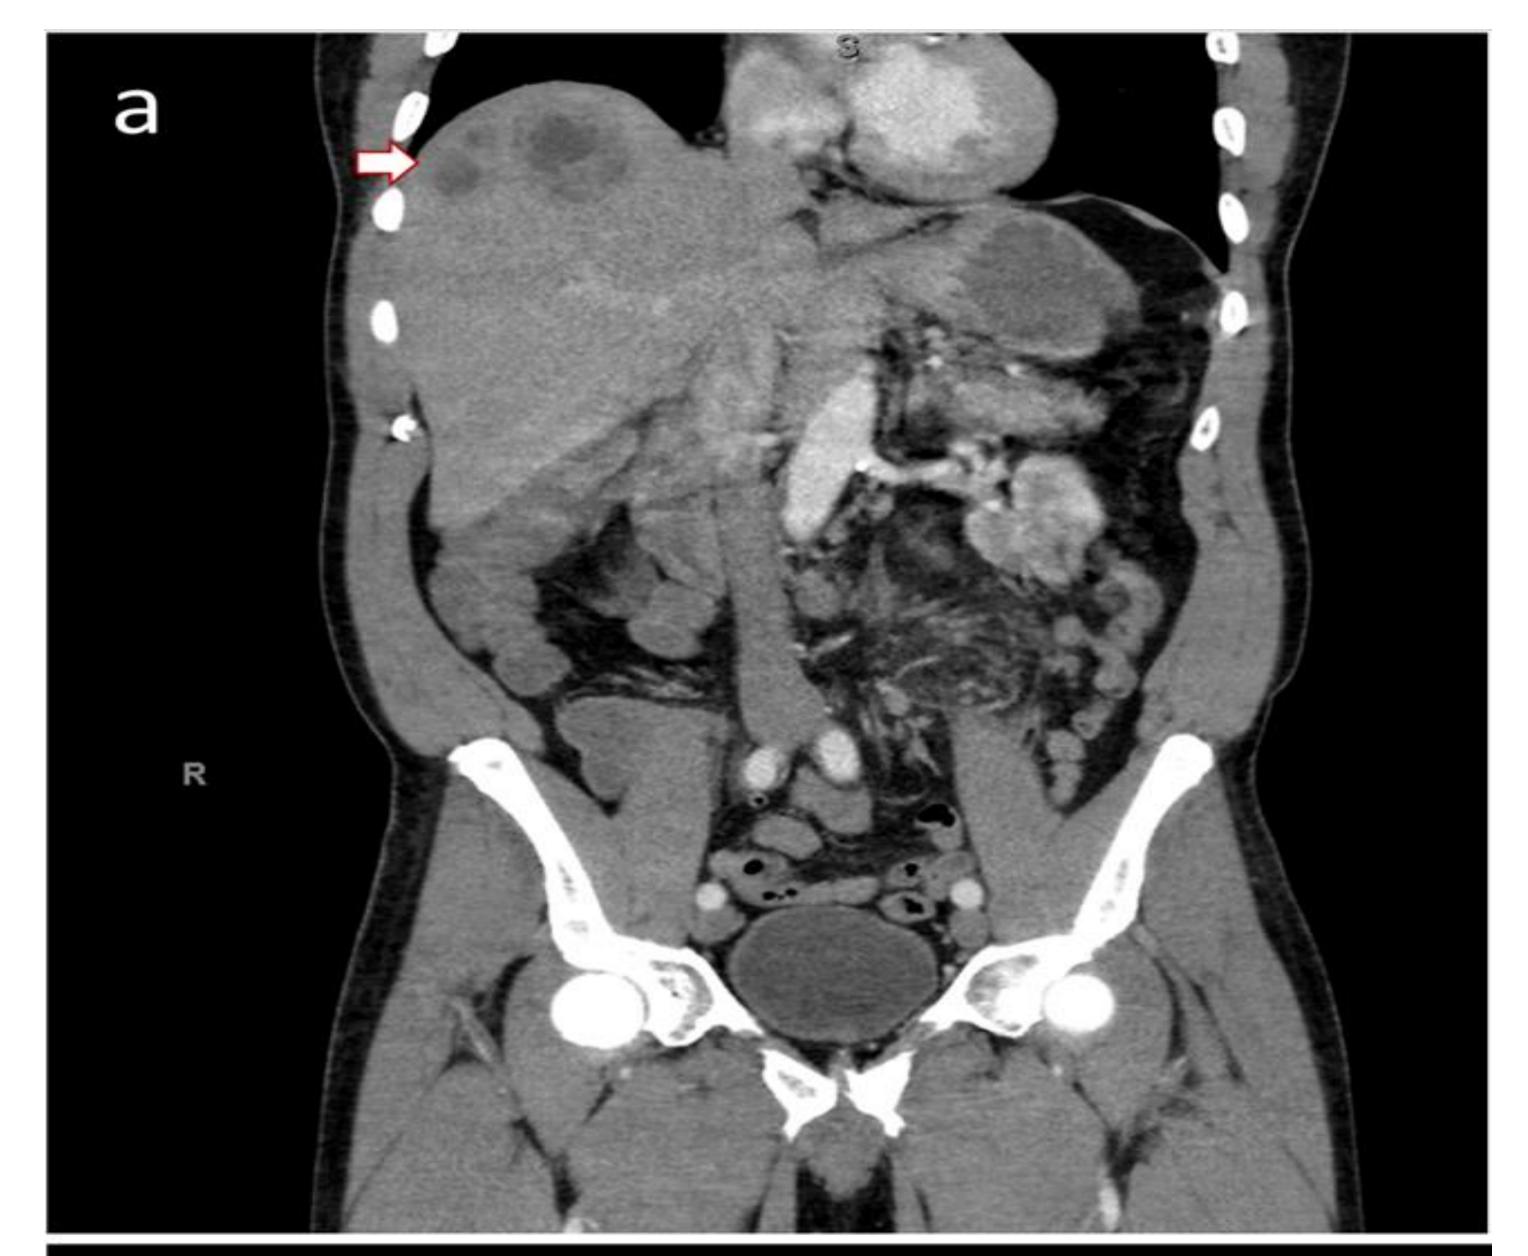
CT Abdomen/Pelvis with IV contrast (coronal view) showing hypodense lesions in right hepatic lobe consistent with liver abscesses (arrow).
